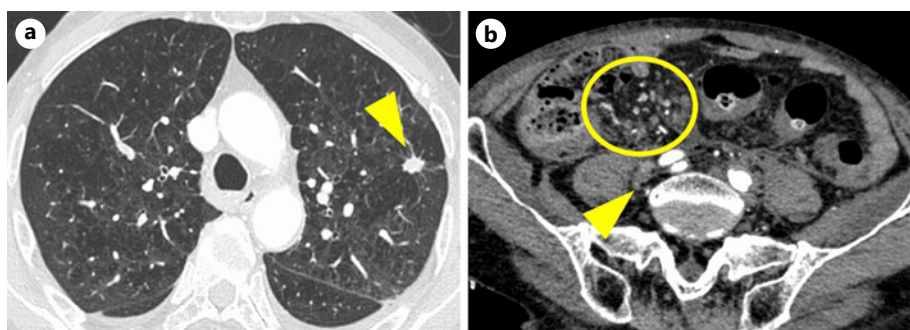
CT findings 3 weeks after the initial diagnosis. A new metastases has appeared: (a) Lung, (b) pelvic lymph node (yellow arrow), and peritoneal dissemination (yellow circle).
